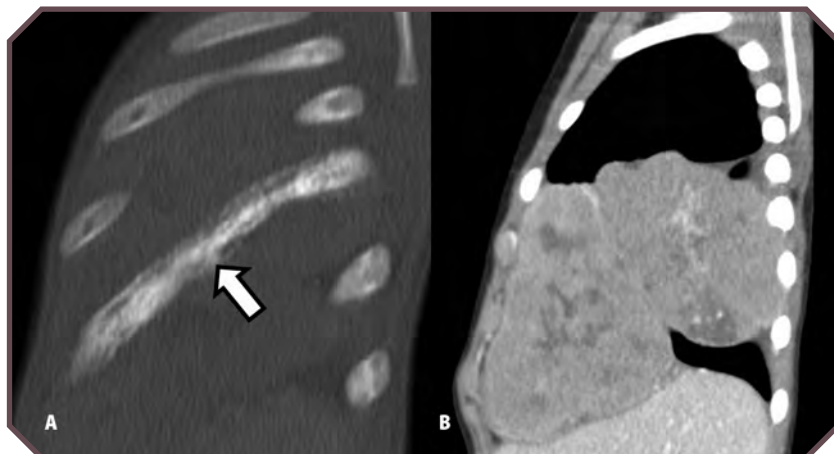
Ewing sarcoma (also termed *Askin tumor*) in a 10-year-old girl with a palpable lump. Sagittal A. reconstructed bone and B. soft-tissue windows from a contrast-enhanced chest computed tomographic examination show a heterogeneous, enhancing mass arising from the fifth rib. Note the extensive periosteal reaction and the moth-eaten appearance of the rib (arrow on A).
